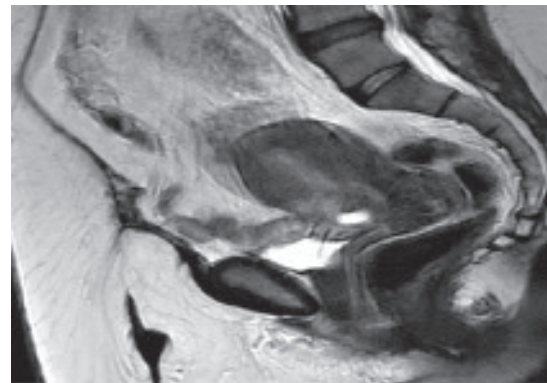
MRI Image of CSP*
